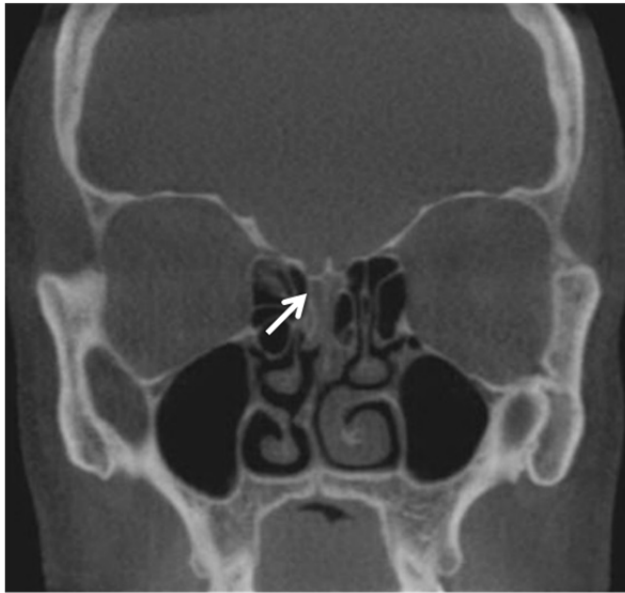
CT-Scan in the coronal plane of a patient suffering from quantitative olfactory disorder. We can note on this picture an opacification of the olfactory cleft (white arrow) whereas there is no obvious rhinosinusitis. This image represents a so-called “olfactory cleft disease”.
